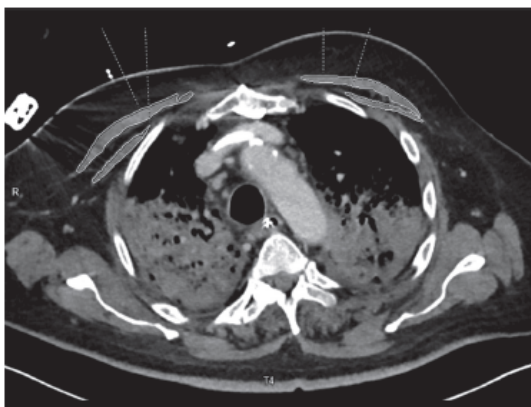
Computed tomography of the thorax of a 67-year-old male patient after contrast injection. The identified muscle parameters were: pectoralis muscle area 18.0 cm<sup>2</sup>, pectoralis muscle index 5.8 cm<sup>2</sup>/m<sup>2</sup>, muscle density 22.5 HU, skeletal muscle gauge 132.3 AU. The patient died after 13 days on Intensive Care Unit.
